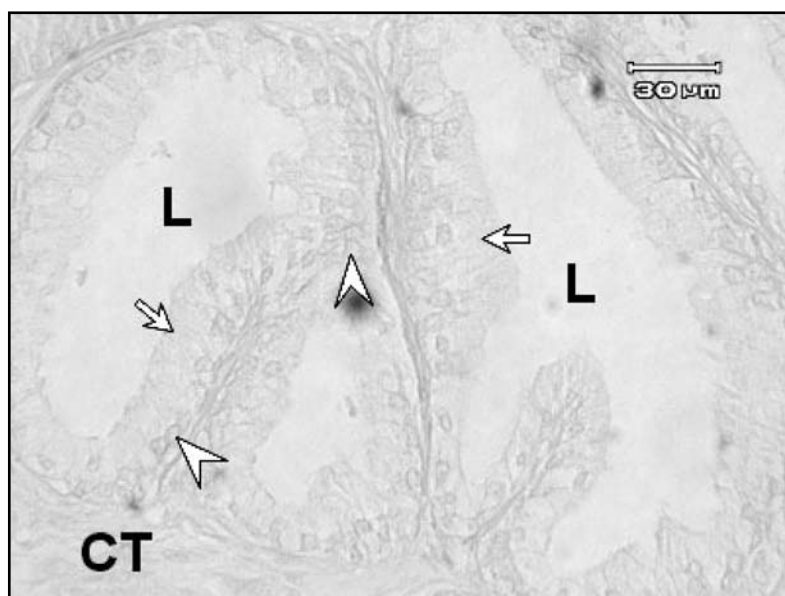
Photograph of the benign prostatic hyperplasia of human prostate gland. Portions of prostatic acini are shown. Control section that has been treated with buffer from which the anti-ubiquitin has been deleted. The cytoplasm (arrows) and nuclei (arrow heads) of the lining epithelium as well as the connective tissue (CT) show a negative reaction for ubiquitin.
